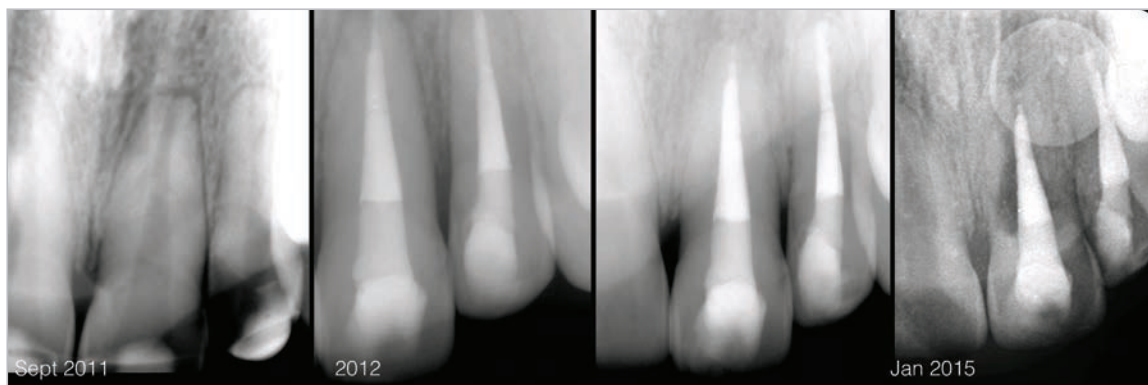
Peri-apical radiographs from 2011-2015 (pre-operative)
